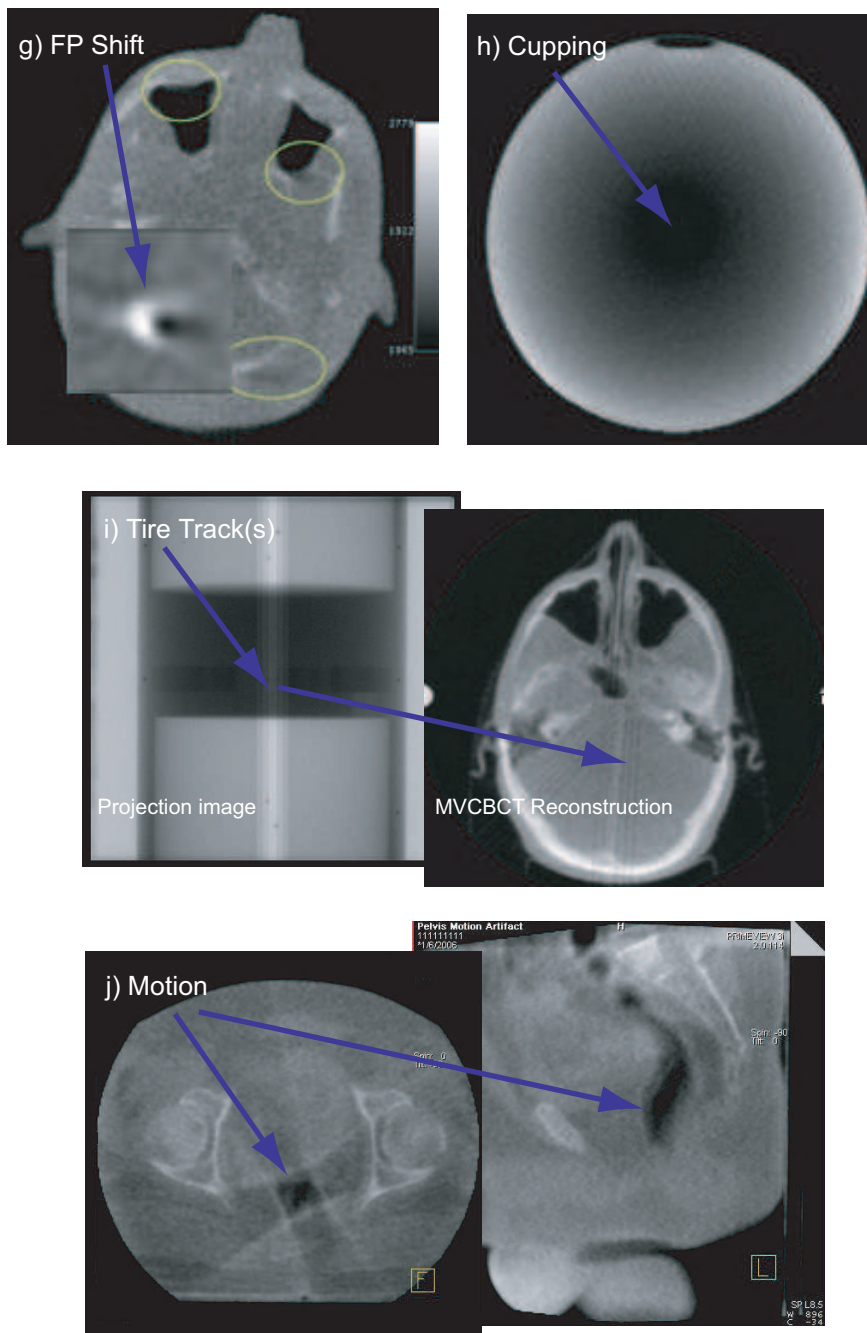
Library of image artifacts possibly occurring with MVCBCT imaging -continued.
